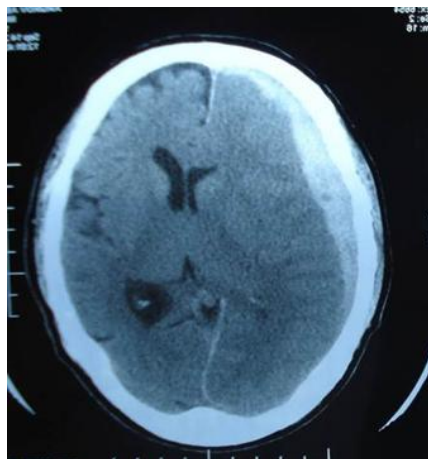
CT image of acute subdural hematoma
